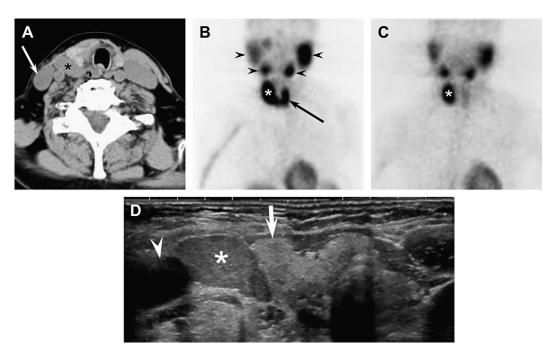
Parathyroid adenoma. (A) Unenhanced CT shows an oval mass (*) uniformly isodense to vessels that might be confused with the internal jugular vein, except that the vein is visible laterally (arrow). (B) Early three-dimensional sestamibi image in frontal projection shows uptake in the mass (*) and physiologic uptake in the salivary glands (arrowheads) and thyroid gland (arrow). (C) Late sestamibi image shows retention of radiotracer in the adenoma (*), with washout (absence) of radiotracer in the thyroid gland. The salivary glands normally retain radiotracer on late images. (D) Sonographic image in transverse plane shows the adenoma (*) with uniform intermediate echogenicity, situated between the right thyroid lobe (arrow) and the carotid artery (arrrowhead).
